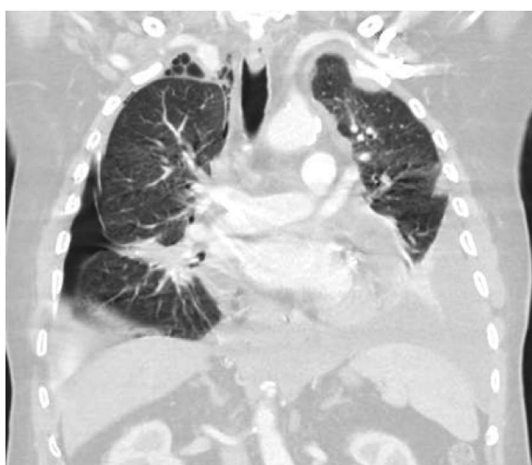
CT Chest coronal view showing right sided hydro-pneumothorax and left sided pleural effusion.
